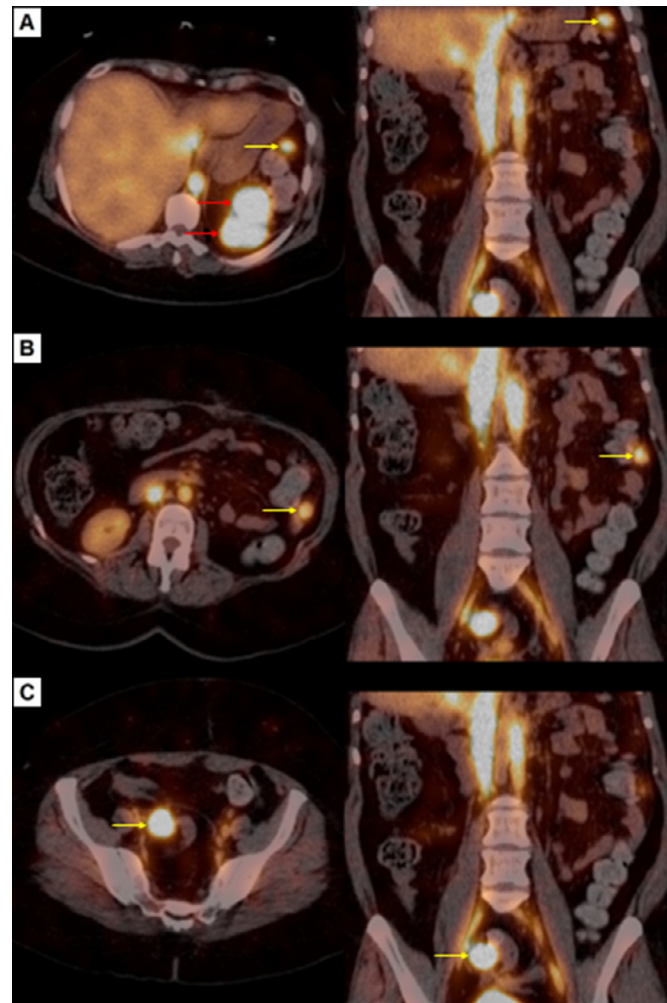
^{99m}Tc -DRBC scan: Superior (A), intermedium (B), and inferior (C) axial slices and corresponding coronal views demonstrating spleen remnants shown as foci of increased radiopharmaceutical uptake in the same locations as the nodules appearing in the abdominal and pelvic CT (yellow and red arrows); labeled erythrocyte accumulation in liver, kidneys, and vessels is considered physiological.
